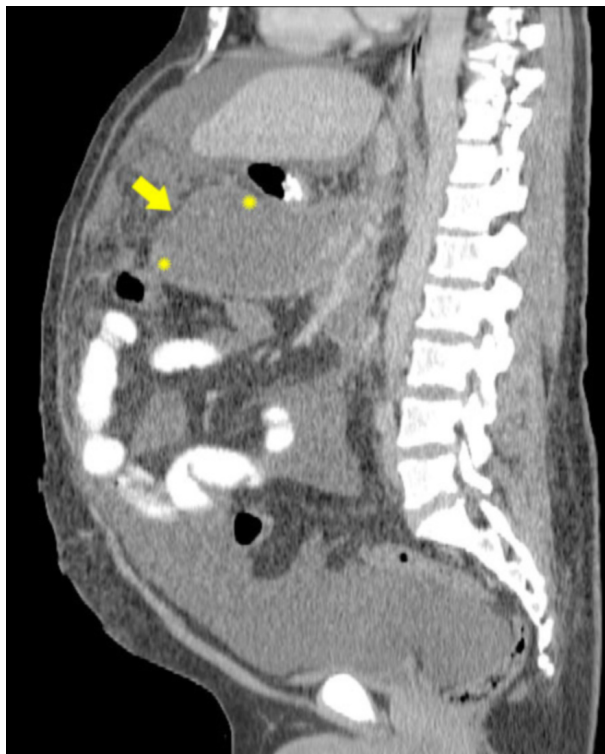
This sagittal CT reconstruction shows the distended lesser sac pressed anteriorly by the presence of the pseudocyst. (Arrow marks the anteriorly displaced gastrocolic ligament. Stars at the pseudocyst border demonstrate the proximity of the pseudocyst to the transverse colon inferiorly and the stomach superiorly.)
